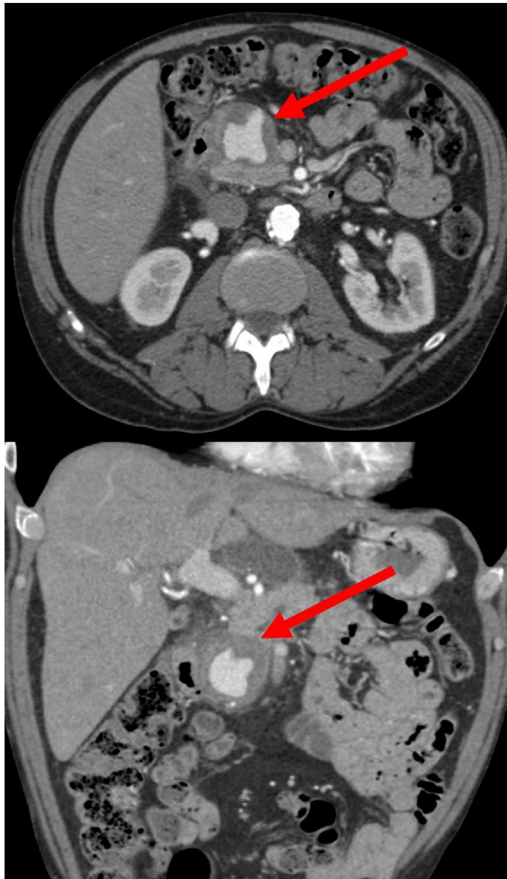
Representative axial (*top*) and coronal (*bottom*) computed tomography images demonstrating visceral artery pseudoaneurysm in necrotizing pancreatitis arising from a branch of the anterior pancreaticoduodenal artery (*arrows*).
